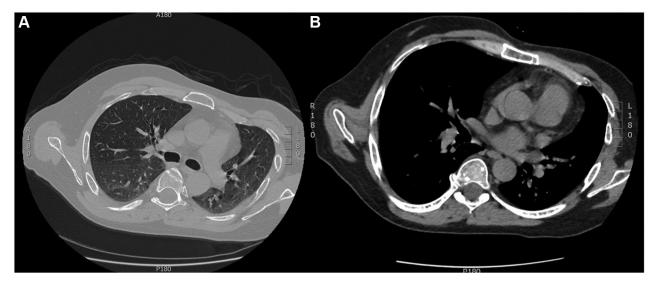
Computed tomography scan of the chest. A, Bilateral ground-glass opacities in the basilar lung zones. B, Hyperdense and irregular foci in the thoracic vertebral bodies suspected as metastatic lesions were also reported.
